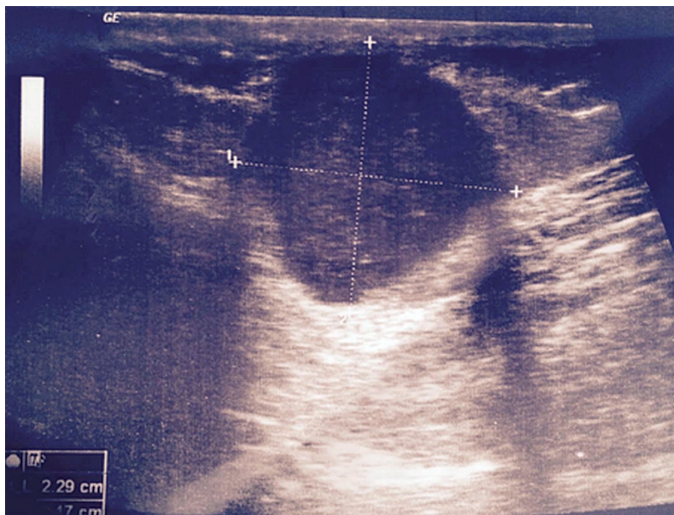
Ultrasonography
